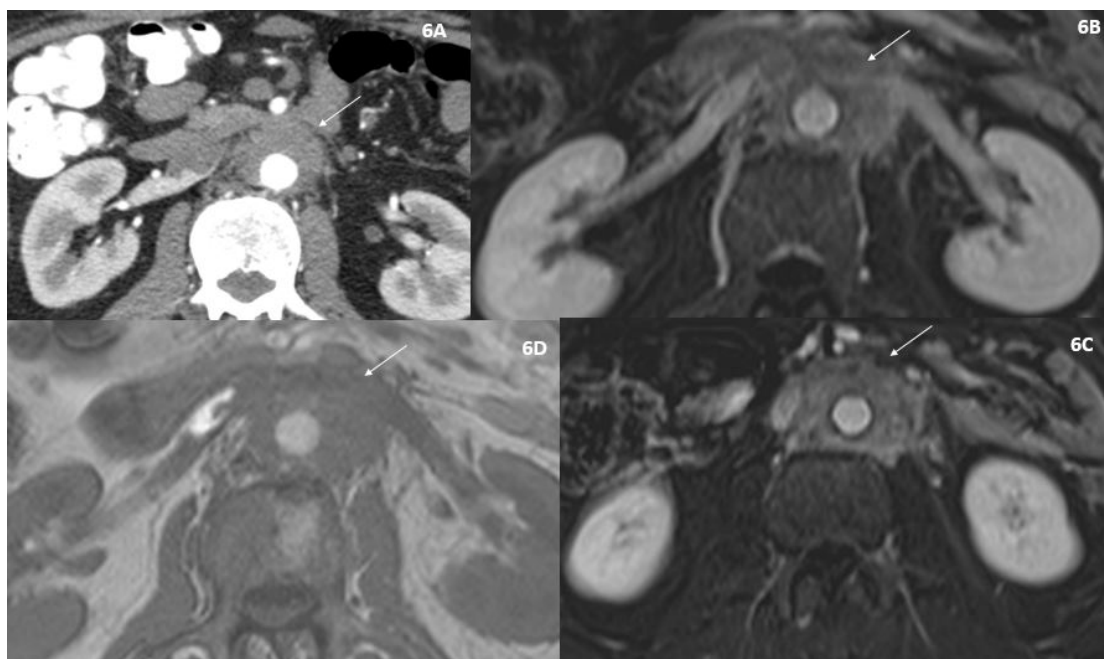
Case 2. Pre-steroid treatment images. A) Pretreatment axial computed tomography image showing soft tissue thickening (indicated by white arrow) along abdominal aorta with encasement of right renal vein. B, C) Pretreatment axial post-contrast image showing soft tissue thickening (indicated by white arrow) encasement of proximal segments of both renal arteries and veins. D) Pretreatment Axial T1W MRI image showing T1 hypointense soft tissue thickening indicated by white arrow
